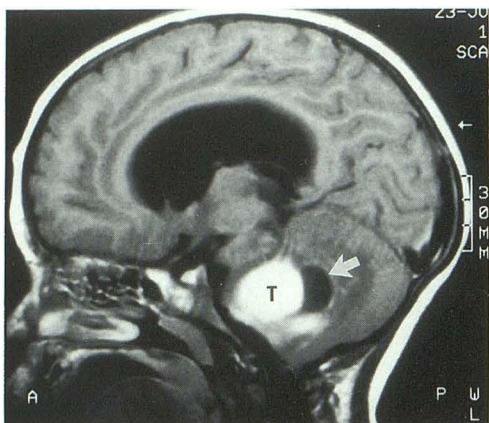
Parasagittal post-gadolinium T1-weighted image showing marked enhancement of the solid portion (T) of this pilocytic astrocytoma. The cyst (arrow) located dorsally, does not enhance.
